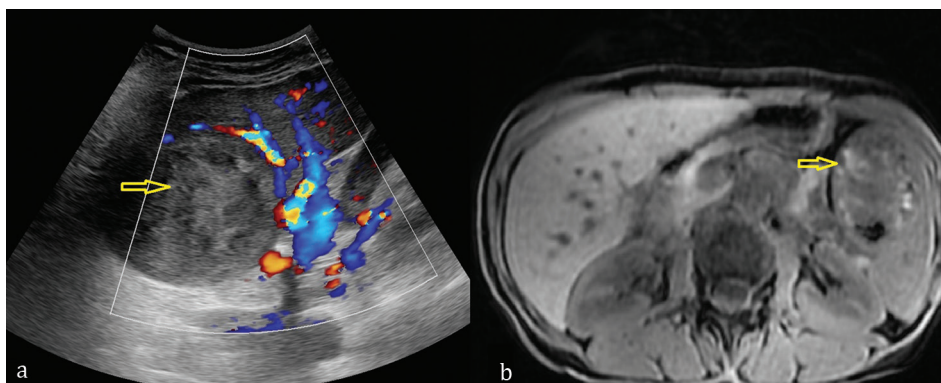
Splenic Gaucheroma: a) ultrasound with Doppler signal: an inhomogeneous focal lesion with mass effect on the surroundings, peripheral vascularization (no specific intra-lesion Doppler signal). b) MRI of the spleen: architectural damage.
